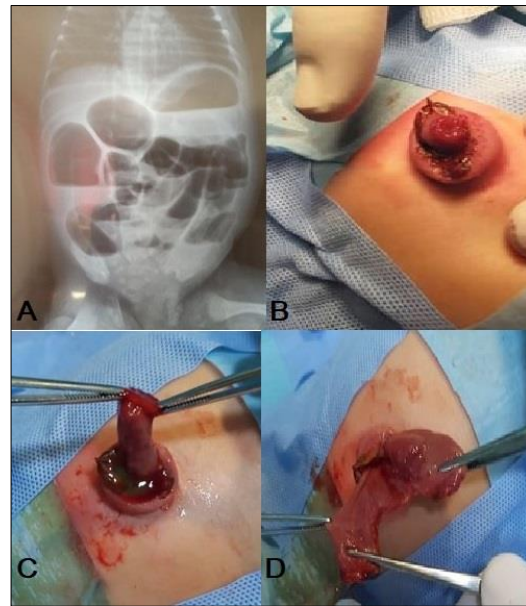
A) Abdominal x-ray showing multiple air-fluid levels. B, C) Transected terminal ileum herniating through the umbilical ring. D) Exploration identified it as terminal ileum.
